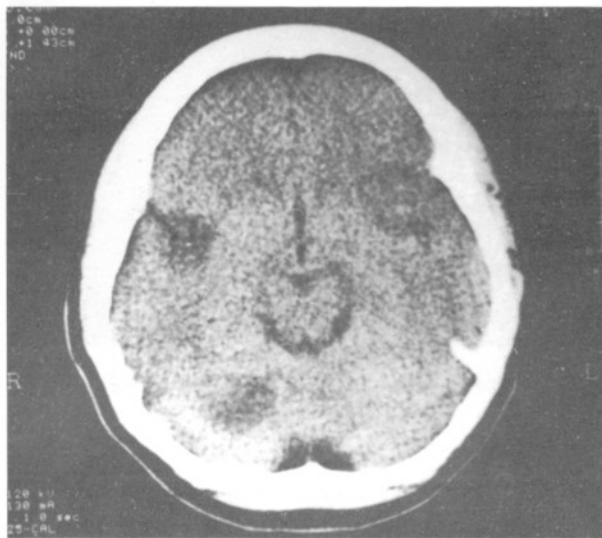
Hypodense areas in the left frontal, right temporal, and right cerebellar areas on the CT performed three days after the admission.
